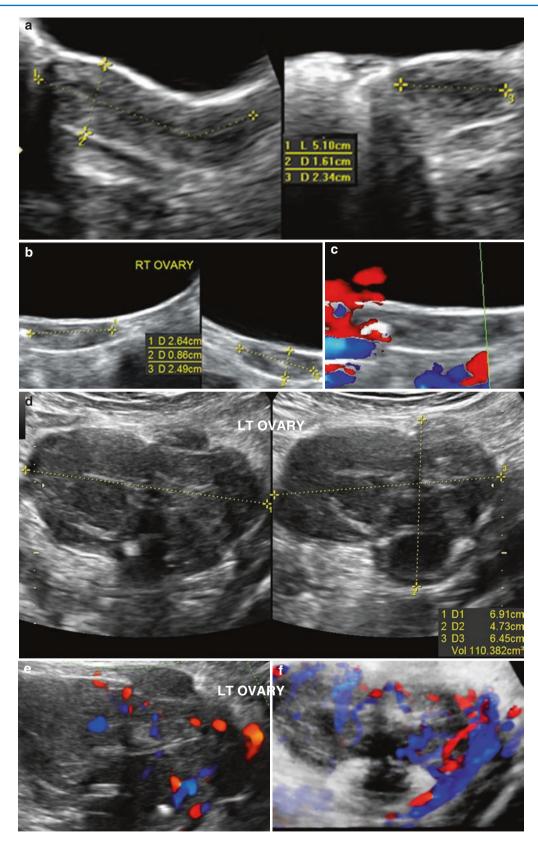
Dysgerminoma and gonadoblastoma in a 20-year-old patient with dysgenetic gonads. Patient gave a history of primary amenorrhoea with periods only on withdrawal of hormonal medication. Transabdominal ultrasound alone was done. (a) Hypoplastic uterus measuring $5.1 \times 1.6 \times 2.3$ cm. (b) Right ovary appears small. (c) No flows seen on Doppler in the right ovary. (d) Left ovary replaced by a nonhomogeneous, hypoechoic, solid mass. The mass shows septae dividing the solid tissue into lobules. It has irregular lobulated outer margins. (e, f) Flow seen in left ovary on 2D Doppler and 3D glass angio mode. *HPE:* left ovary showed dysgerminoma probably overgrown on a background of gonadoblastoma. Right ovary showed features suggestive of gonadoblastoma with a small focus of dysgerminoma
